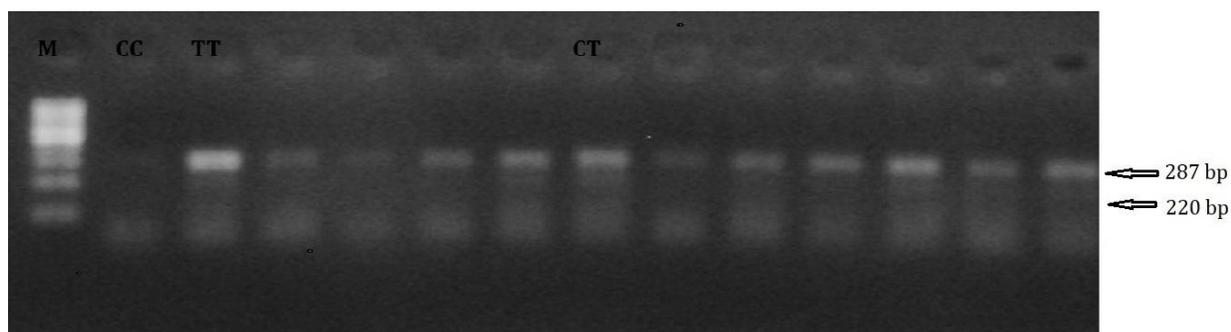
PCR-RFLP analysis of the KCNQ1 rs2237892 locus revealed two bands of 220 bp and 67 bp in the CC homozygote genotype, one band of 287 bp in the TT homozygote, and three bands of 287 bp, 220 bp, and 67 bp in the CT heterozygote genotype. M = 100 bp ladder DNA marker.
